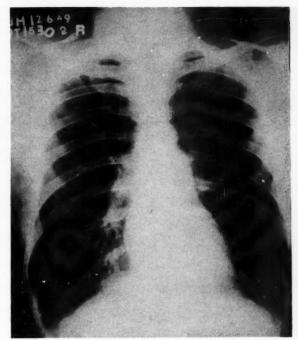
Case II. X-ray of the chest.
